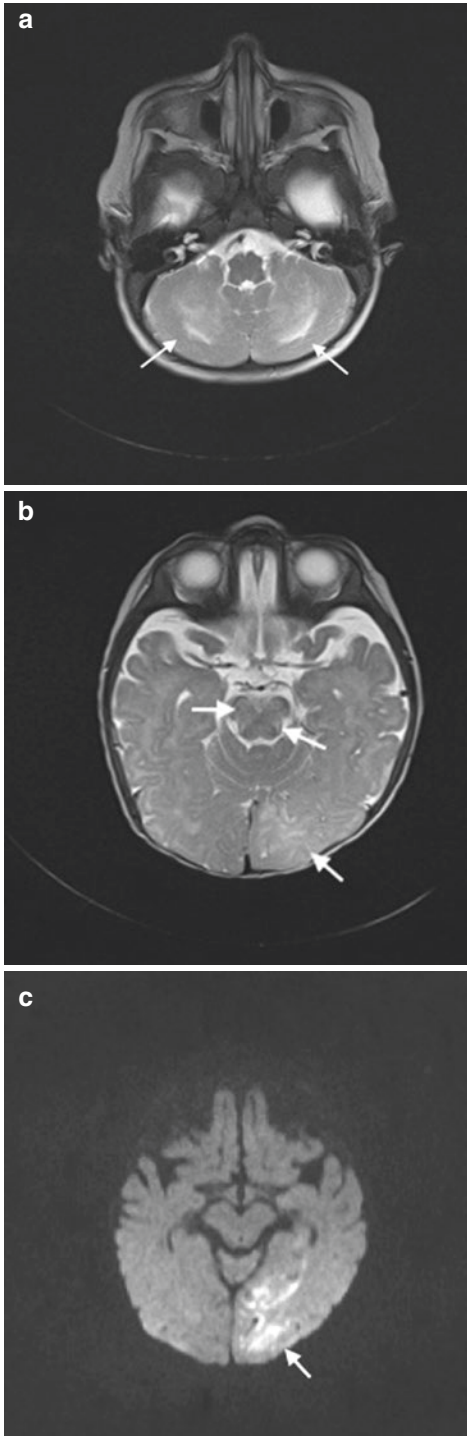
Neuroradiological MRI findings in HLH (arrows are indicating the lesions). (a) T2w image showing bilateral hyperintense lesions in the cerebellum. (b) T2w image with hyperintense signal and edema in the left posterior hemisphere and abnormalities in the brainstem. (c) Diffusion-weighted imaging of the same region as in (b) with lesions imitating cerebral infarction
